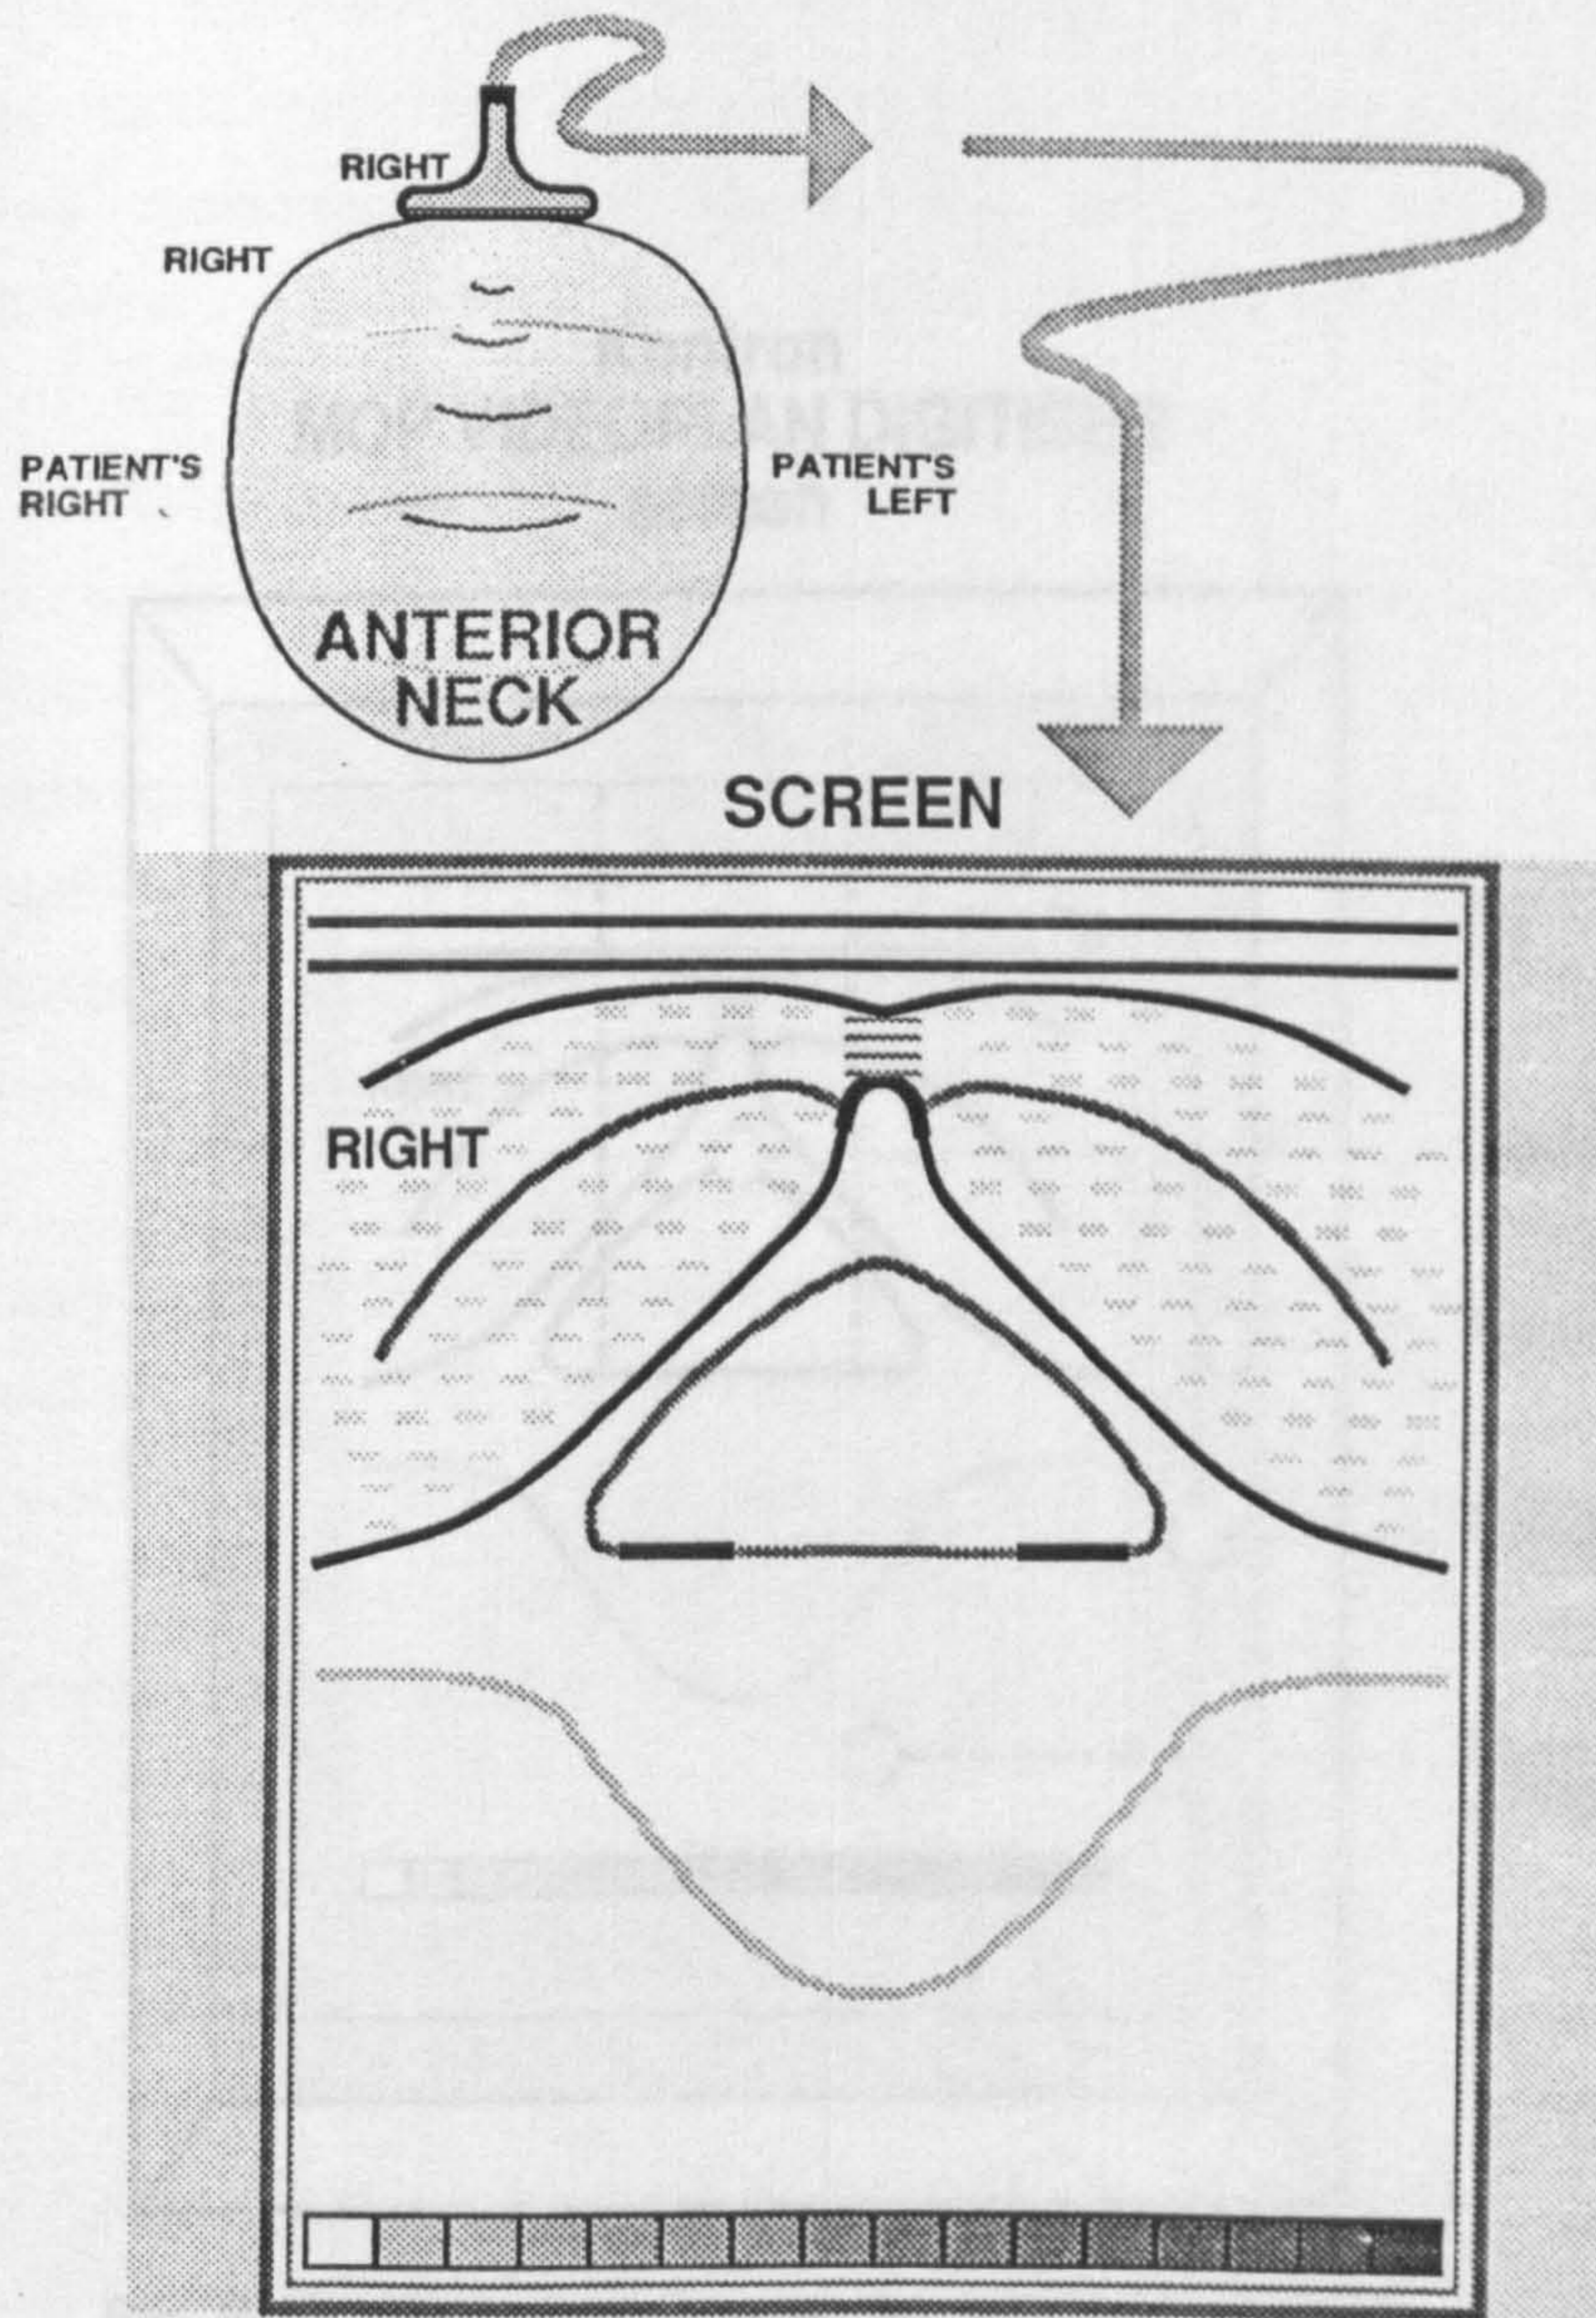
Representation of the neck showing probe position and orientation of ultrasound scan image
